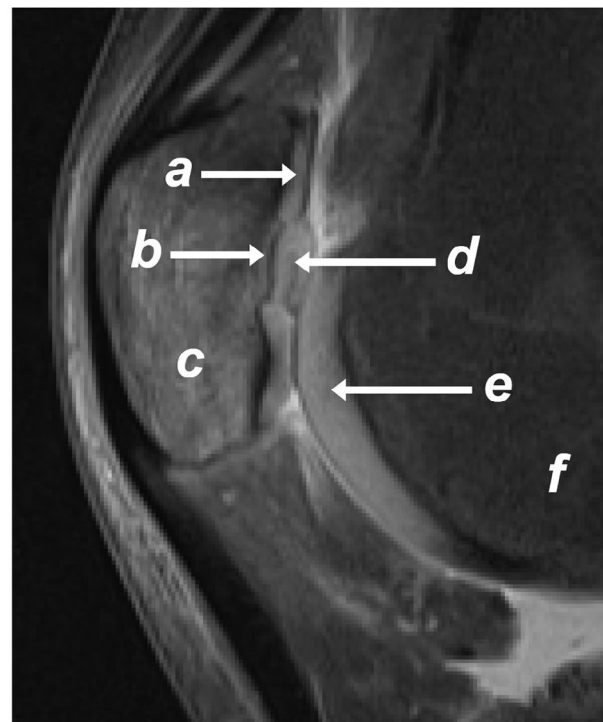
Magnetic resonance image of the right knee joint of a 21-year-old man 6 months following arthroscopic abrasion arthroplasty of a chondral defect at the patella. Normal articular cartilage neighbouring the defect site can be identified proximal (a) and distal to the defect on the dorsal surface of the patella (c) as well as on the condylar circumference of the distal femur (f). Note the significant upward migration of the subchondral bone plate within the former defect area (b), which is covered by an irregular cartilaginous repair tissue (d) protruding into the patellofemoral joint.
